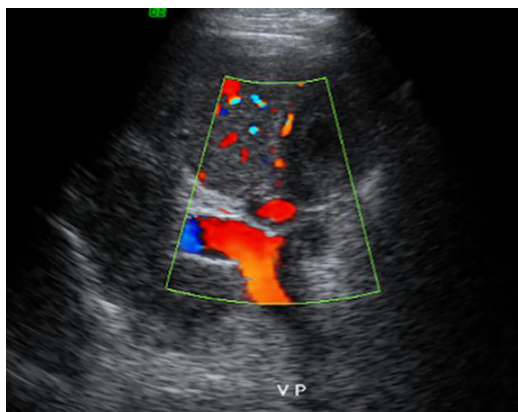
Abdominal ultrasound showing an enlargement of the portal vein trunk and parietal irregularities due to partial thrombosis (yellow arrow) and periportal hyper echogenicity compatible with periportal fibrosis (blue arrow)
